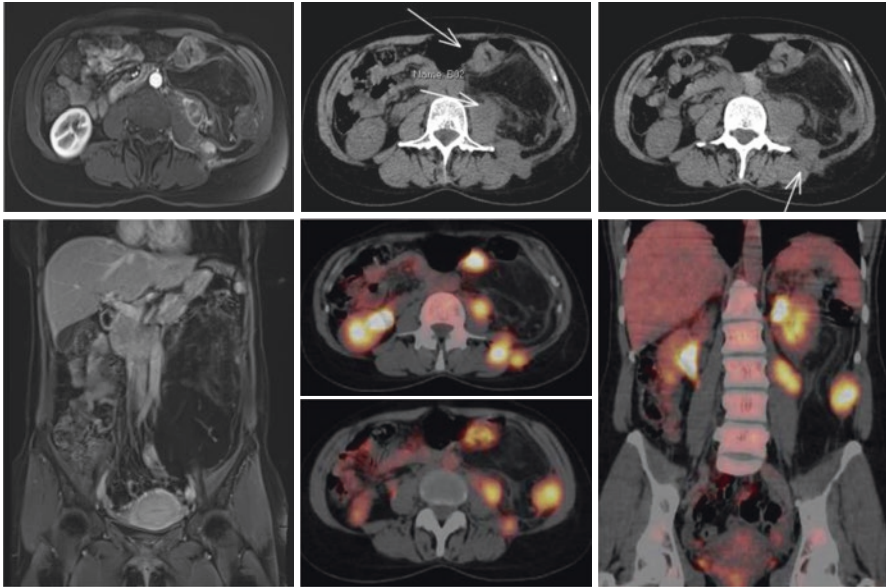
Large retroperitoneal liposarcoma with well-differentiated areas and foci of dedifferentiation, evident in PET-CT. This type of finding can be misinterpreted as a multifocal disease and lead to a contraindication to surgery due to suspected sarcomatosis; however, it is a single lesion
